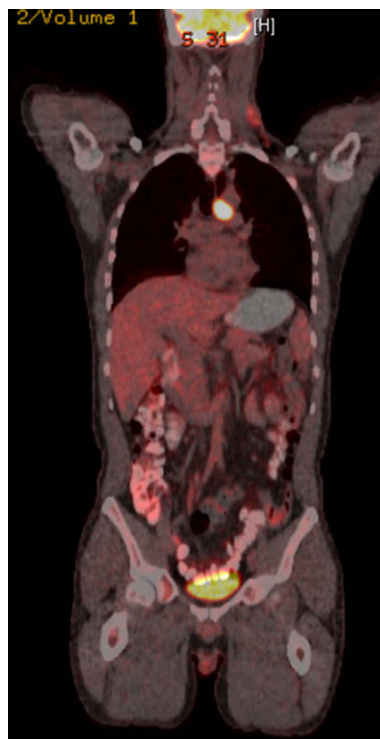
Positron emission tomography and computed tomography (PET–CT) of a newly diagnosed patient with follicular lymphoma (FL). Aorto-pulmonary node had a standardized uptake value of 21.2 compared to 5.4 for a left inferior cervical node. The pathology of the aorto-pulmonary node showed FL, grade 3a. (Color plate 46.2)
